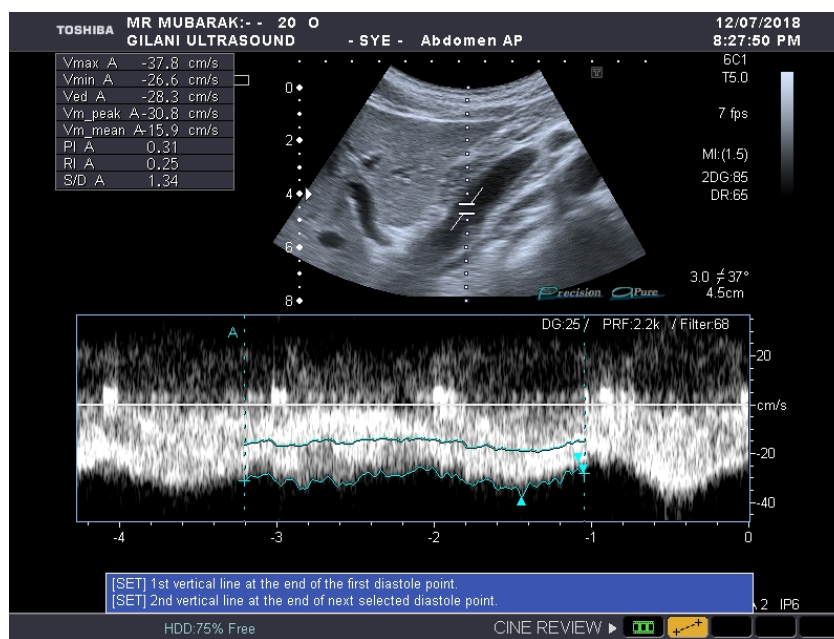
Ultrasound image showing an increased congestive index of the portal vein in CLD.
